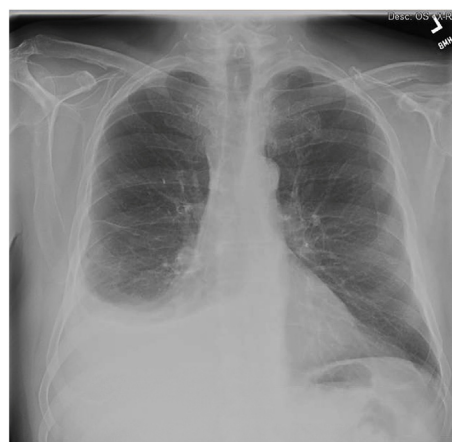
Plain radiograph with decreasing right pleural effusion.
